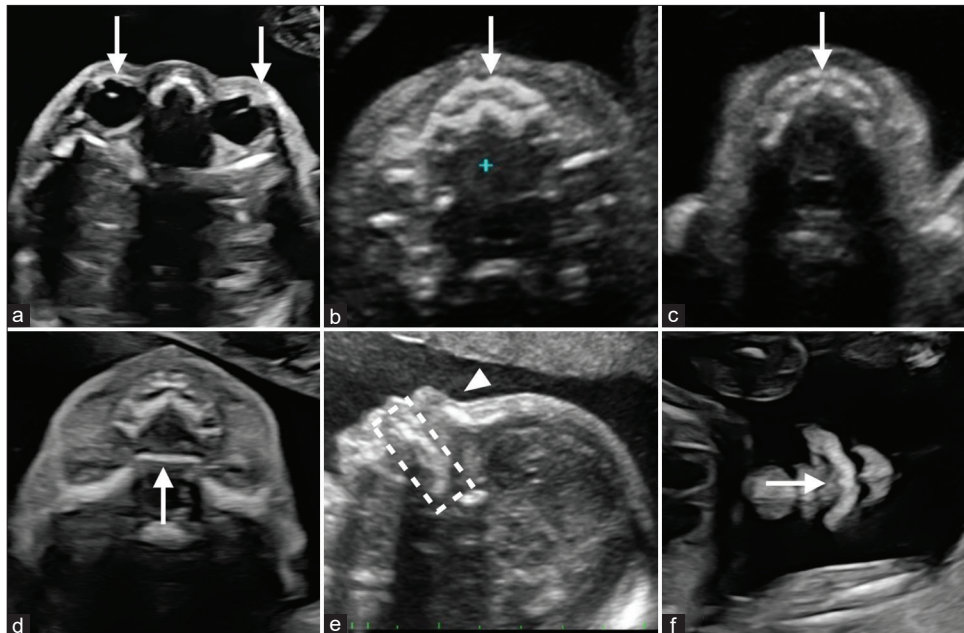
A series of two-dimensional grayscale ultrasound images for basic orofacial cleft (OFC) screening. A stepwise basic screening for OFCs includes visualization of: the eye sockets (arrows, a), maxillary alveolus (arrow, b), mandible (arrow, c), and the posterior edge of the hard palate (arrow, d) in the axial view. Besides the axial view, the facial profile was obtained in true sagittal view to visualize the nasal bones (arrowhead, e), and maxillary alveolus (dashed rectangle, e). Finally, the fetal lip was imaged in the coronal view (arrow, f)
